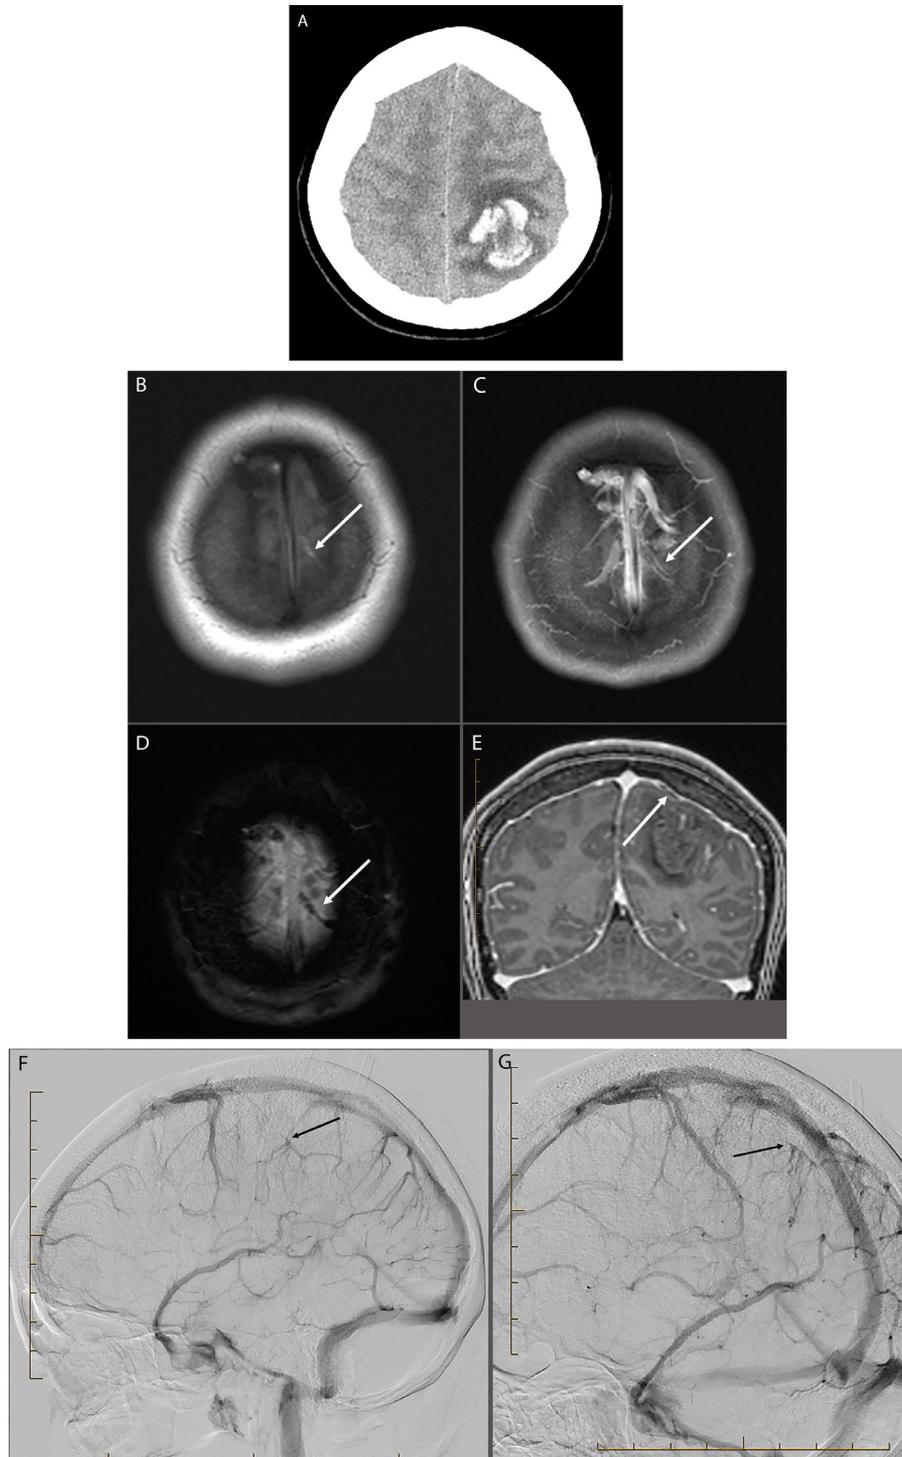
Cerebral venous thrombosis: 25-year-old female with headache, recently COVID positive. (A) Head CT showed left parietal lobe hemorrhage. (B) Unenhanced T1-weighted axial image at the vertex of the head shows a linear hyperintensity (white arrow) to the left of midline, corresponding to a superficial left anterior parietal cortical vein suggesting subacute thrombus. (C) Post-contrast T1-weighted axial image at the same level demonstrates the same vein containing a filling defect (white arrow) suspicious for presence of thrombus. (D) Axial susceptibility-weighted image (SWI) at the same level confirmed blood products in this cortical vein (white arrow). (E) Coronal T1-Weighted post-contrast image from reformatted volumetric acquisition demonstrates the filling defect (white arrow), supporting the diagnosis of CVT. Diagnostic catheter cerebral angiogram to evaluate the etiology of hemorrhage. (F) Lateral projection from the venous phase of catheter angiogram after injection of the left ICA shows an abrupt cut-off (black arrow) of the left parietal cortical draining vein. (G) Right anterior oblique projection of the same injection again shows the abrupt cut-off (black arrow) of the same left parietal cortical vein consistent with CVT. *Images courtesy of Dr. David D. Pasquale, MD.
